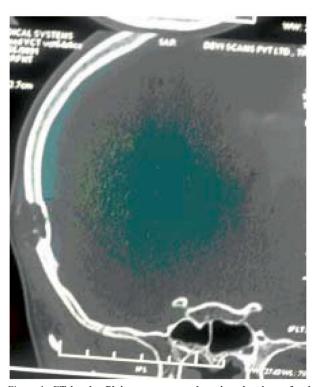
CT head – Plain scan - coronal section showing a focal osteolytic lesion in the ® high temporal region with interruption of the outer table and intact inner table of the skull.
